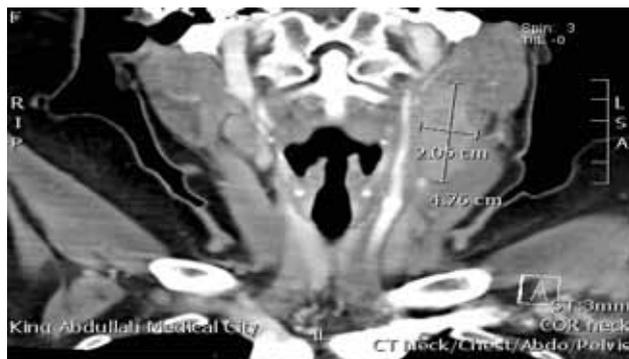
CT Neck (relapse post 8 cycles of paclitaxel/carboplatin)
